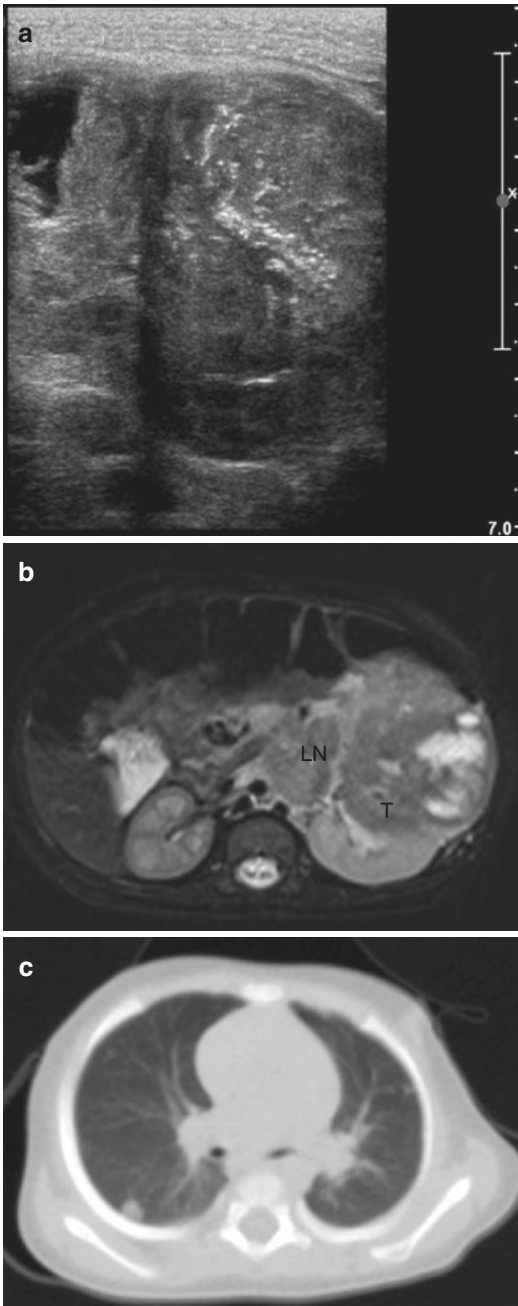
A 5-month-old girl presented with a palpable mass in the left flank and an episode of macroscopic hematuria. US shows a solid left renal mass containing linear calcifications (a). On fat saturated T2-weighted MRI the tumor (T) shows a close relation to the left renal pelvis and several large lymph around the renal hilum (LN) (b). Lung metastases were present at diagnosis (c). The child also had a synchronic brain tumor (not shown). Pathology examination revealed a malignant rhabdoid tumor of the kidney
